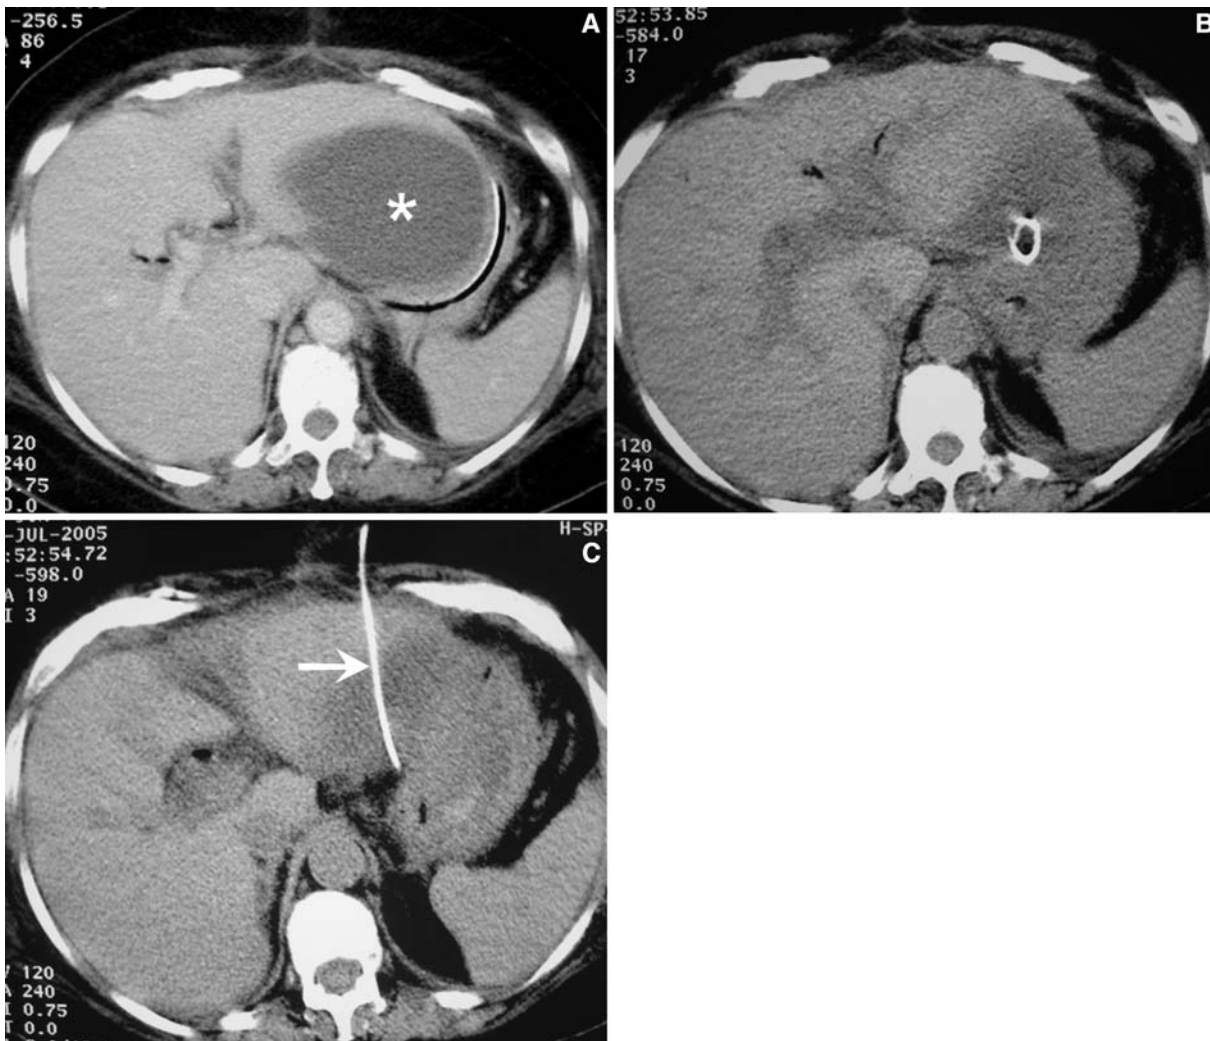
Drainage of fluid collection. A Postoperative fluid collection (*asterisk*) displacing the stomach. B, C At CT control after US-guided transhepatic placement of a small (5.7-Fr) drainage (*arrow*), the fluid collection is reduced in volume.
